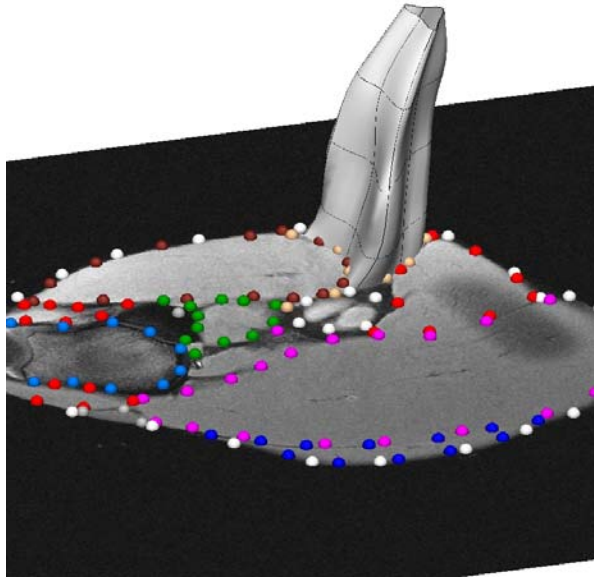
The surface mesh of the semitendinosus with a CT image showing the digitized data points for the various muscles and bones within the segment
